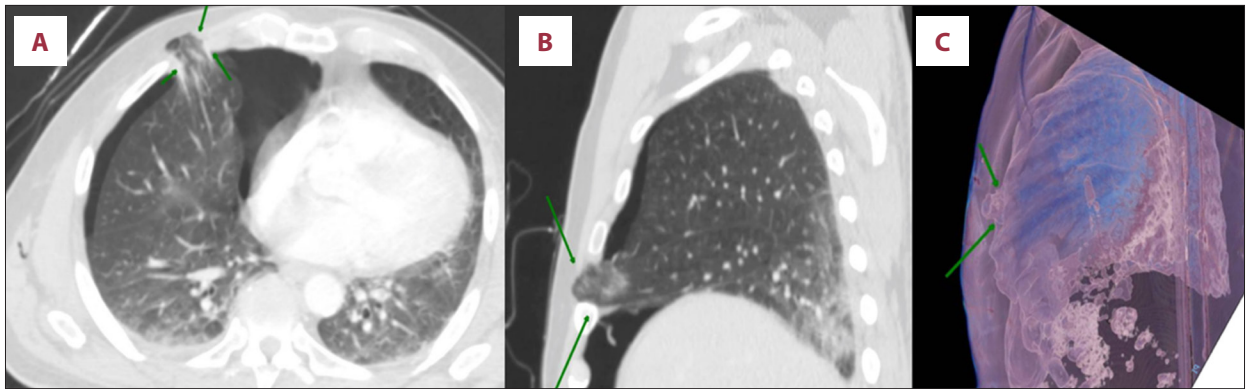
Follow-up chest computed tomography (CT) scan performed in the Emergency Department: (A) contrast-enhanced chest CT performed the day of admission showing a moderate right pneumothorax with a concomitant anterior chest wall defect through which a portion of the right middle lobe is herniating (arrows); (B, C) sagittal and 3-dimensional reconstruction showing the same anterior wall defect and consequent intercostal hernia of the right middle lobe (arrows).
